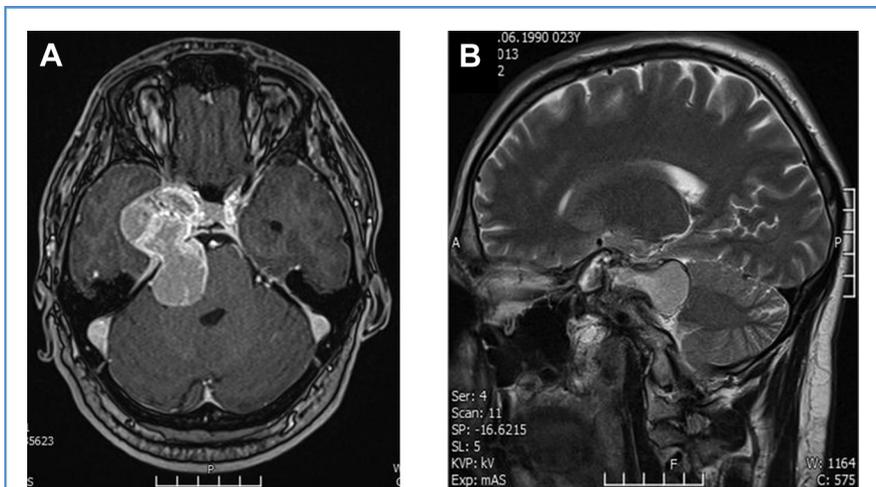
(A) Axial T1-weighted magnetic resonance imaging with gadolinium. (B) Sagittal T2-weighted magnetic resonance imaging. The lesion has smooth contours and a thin capsule. There is a hyperintense signal on T1- and T2-weighted images relative to the signal intensity of the brain. The homogeneous enhancement on T1-weighted images after the administration of gadolinium can be observed.
